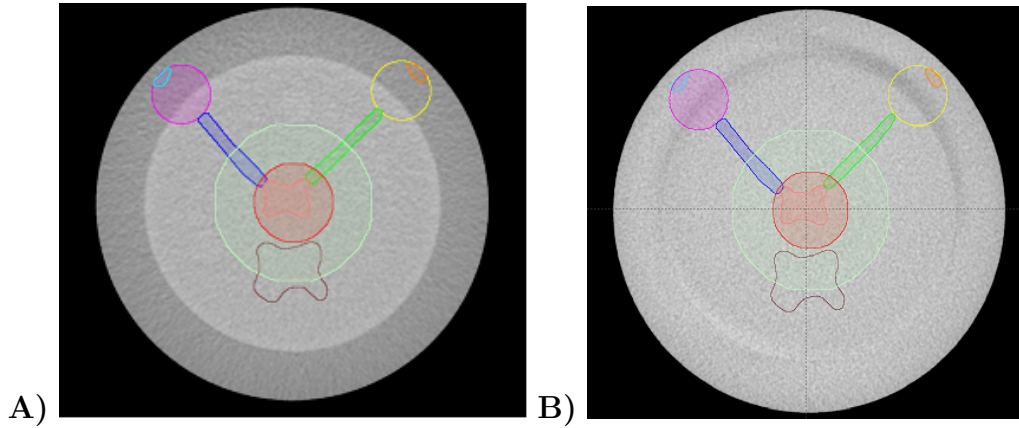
A) CT B) CBCT images of the Catphan with hypothetical structures RT Eye (magenta), RT Lens (cyan), LT Eye (yellow), LT Lens (orange), RT optic nerve (blue), LT optic nerve (green), Chiasm (pink) Brainstem (brown) ,  $R_1$ (red) and  $R_2$  (light green).
